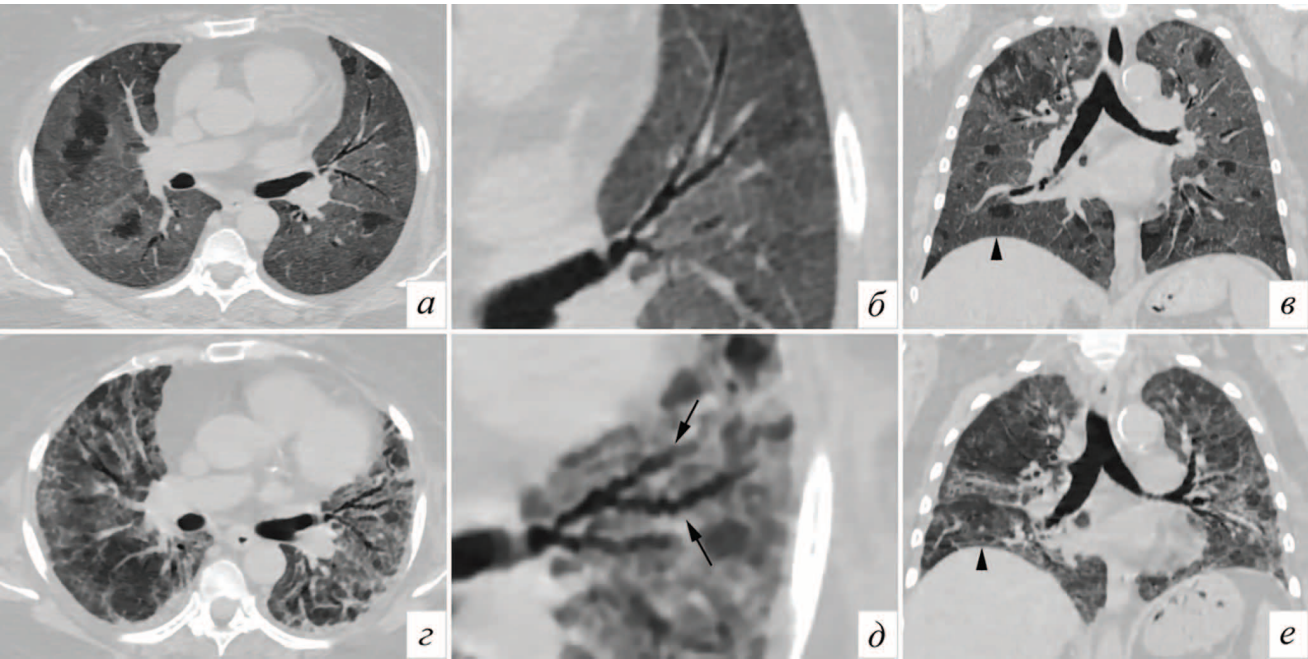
Patient F., 60 years old. COVID-19 (PCR+). Thoracic CT scans in axial projection (a, г), coronal projection (б, д) and enlarged fragments (в, е) at appropriate levels. The upper row — the study dated 23.11.2020, the lower row — the study dated 25.12.2020. Against the background of heterogeneous hardenings in both lungs, the appearance of traction (varicose) bronchiectase in the upper lobe on the left (arrows) are clearly visible, which were absent before. In other parts of the lungs there is no such deformation. Also, in the dynamics there is a general decrease in lung volume at the same depth of inspiration (в, е), a high position of the dome of the diaphragm (arrowheads). The changes may be potentially reversible
